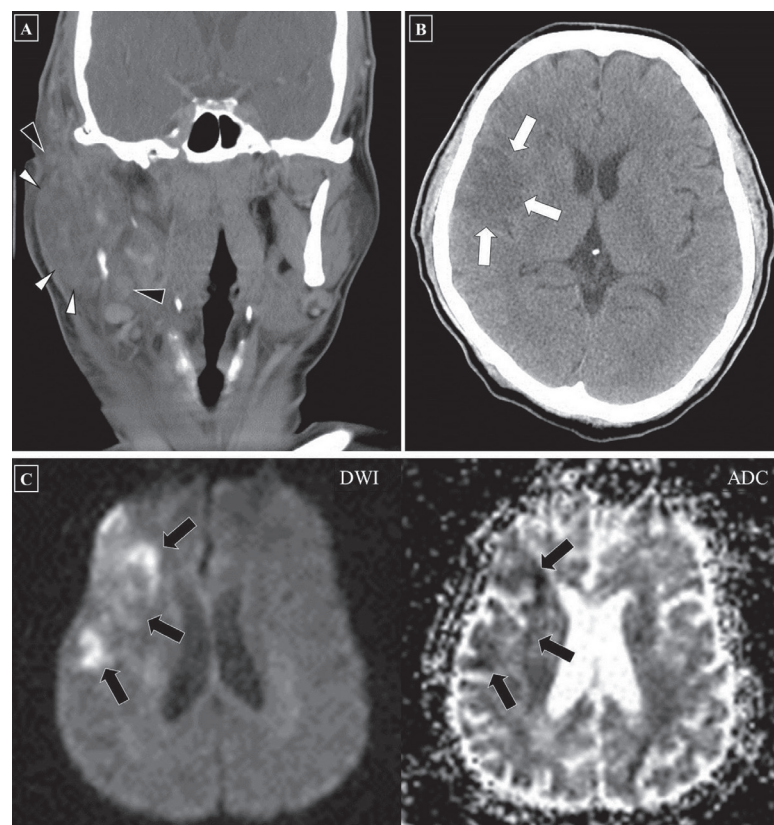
(A) The first contrast enhanced computed tomography revealed enhanced inflammatory swelling of right parotid gland (hollow arrowheads) and enhanced surrounding lymphadenopathies (filled arrowheads). (B) The emergent brain computed tomography revealed a hypodense area at right frontal lobe (hollow arrows). (C) Magnetic resonance imaging demonstrated an acute infarction in right frontal lobe (filled arrows), which was high-intensity signal lesion at diffusion weighted imaging (DWI) (TR/TE/excitation: 9,212/144/1) and low-intensity signal lesion at apparent diffusion coefficient mapping (ADC) (TR/TE/excitation: 9,212/144/1).
